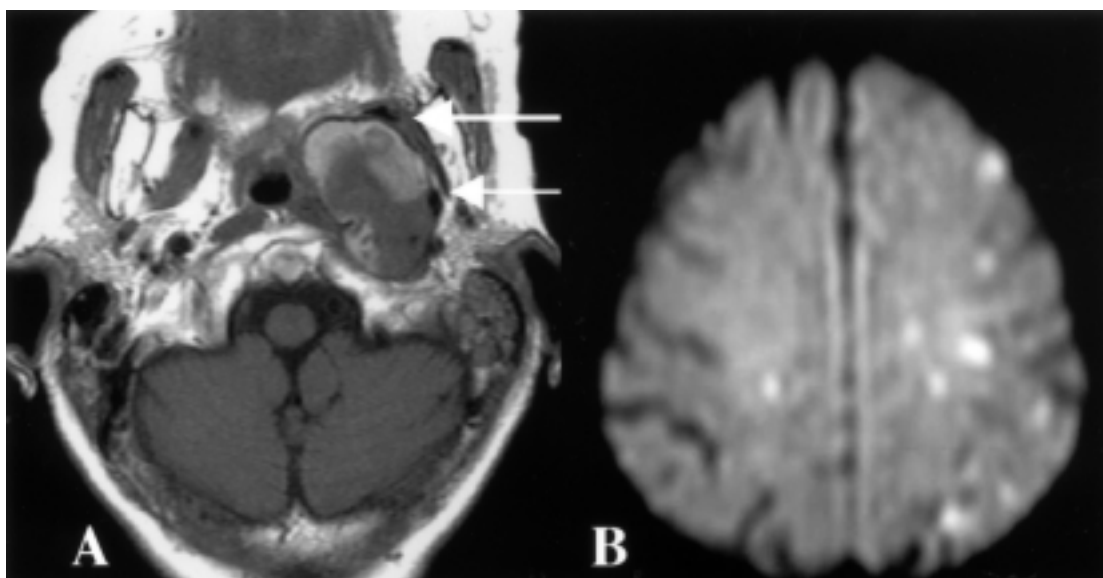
MRI shows the location of the internal carotid artery (arrows) and the kystic mass, identifying it as a dissecting aneurysm (A). Diffusion-weighted MRI shows multiple high intensity areas in the left internal carotid territory and one in the right internal carotid territory (B).
